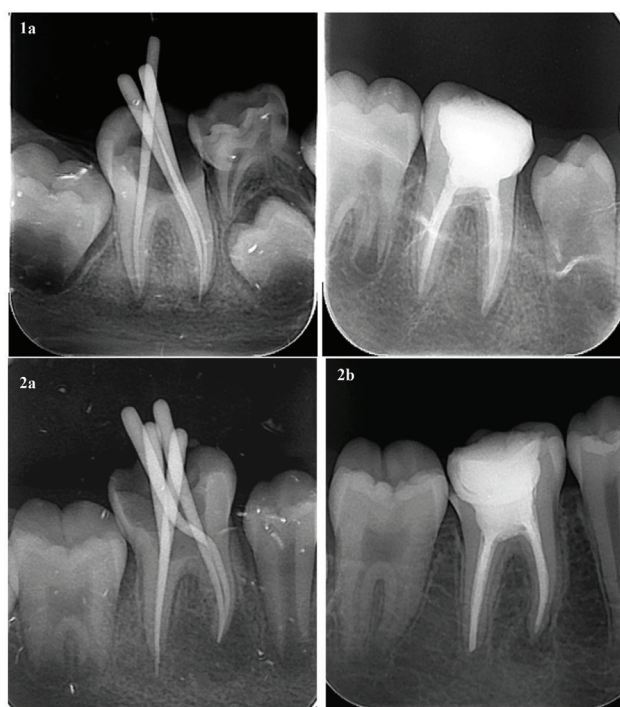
Before and after the root canal treatment (RCT) periapical radiographs of the teeth
